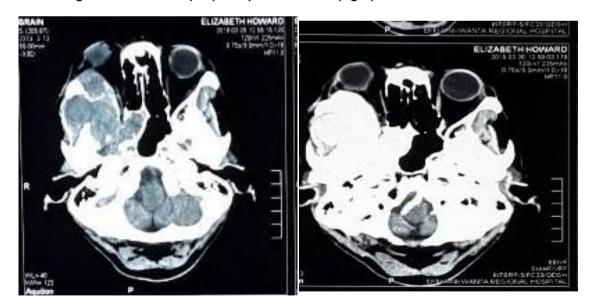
Pre-contrast (left) and post-contrast (right) CT scan of sphenoid ridge mass
